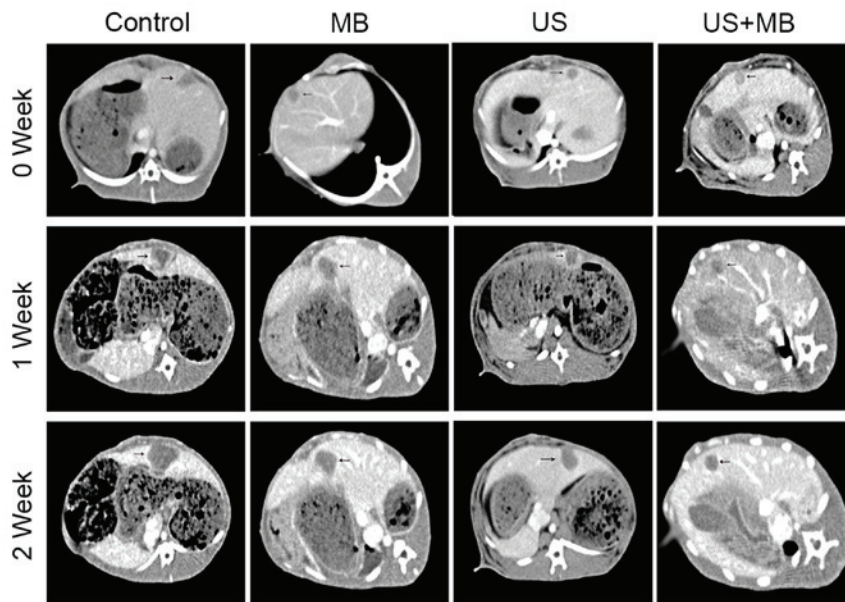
Representative computed tomography images of tumors (arrows) prior to and following treatment in the control, MB, US and US + MB groups. US, ultrasound; MB, microbubble.
